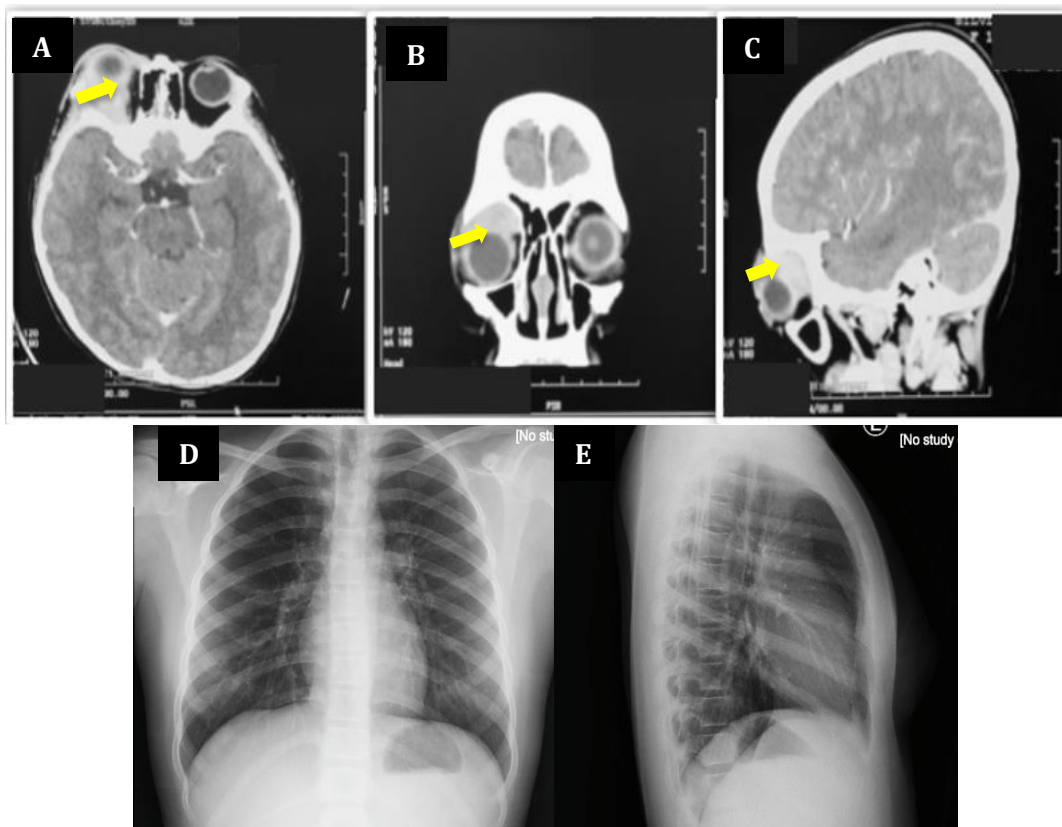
Contrast-enhanced Computed Tomography (CT) of the head and orbit one month prior to the presentation (upper panel) and preliminary chest X-ray (lower panel). Axial (A), coronal (B), and sagittal planes showed right-sided proptosis and enhancement lesions (yellow arrows) without bony involvement. Both anteroposterior (D) and lateral views of the chest X-ray reveal no lesions suggesting any active lung infection.
